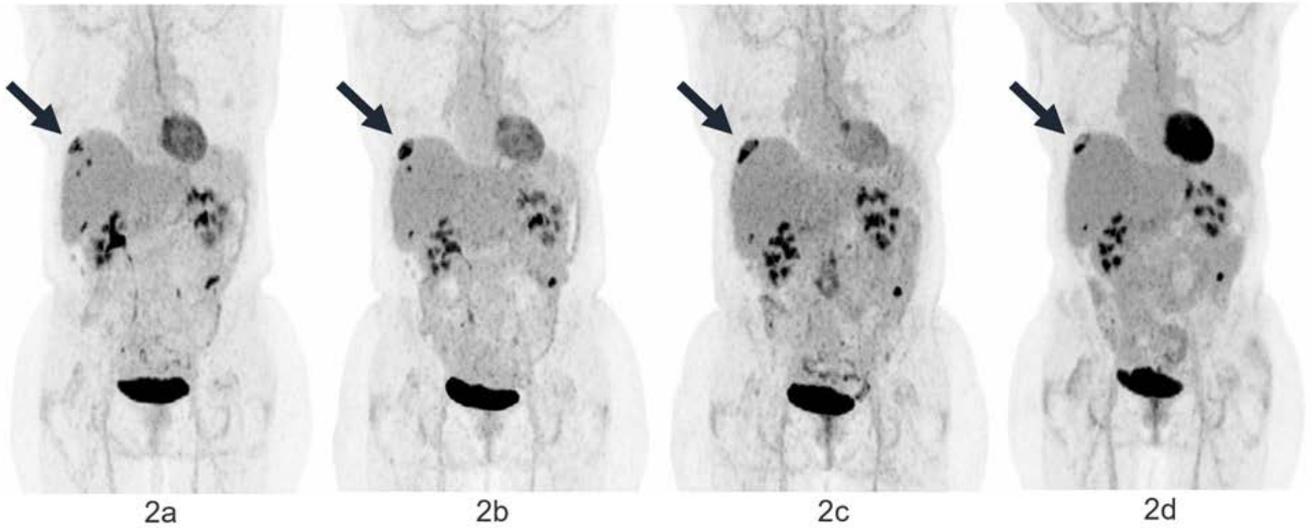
65-year-old woman primarily operated for adenocarcinoma of the colon. The figures (2a-2d) show four follow-up FDG PET scans. The dosage of FDG is body-weight based and was between 270-280 MBq. Timing and findings were as follows:
